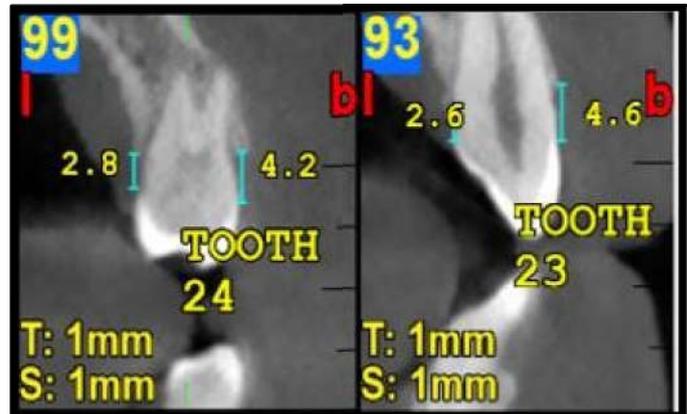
Pre-OP CBCT IBD Measurements
